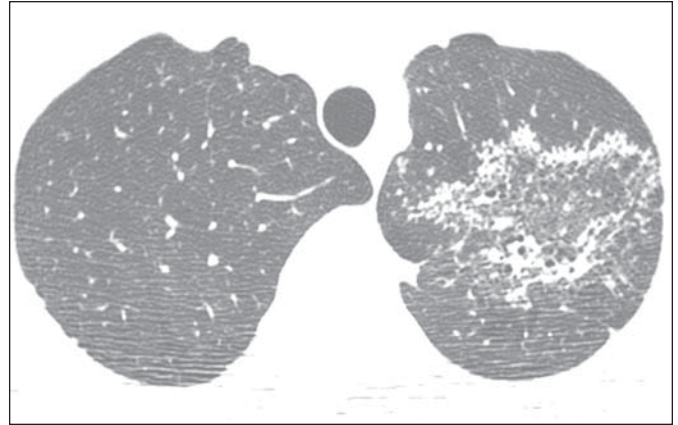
36-year-old man with pulmonary tuberculosis. High-resolution CT scan of upper pulmonary regions shows reversed halo sign in left upper lobe with nodular walls and nodules inside halo.
